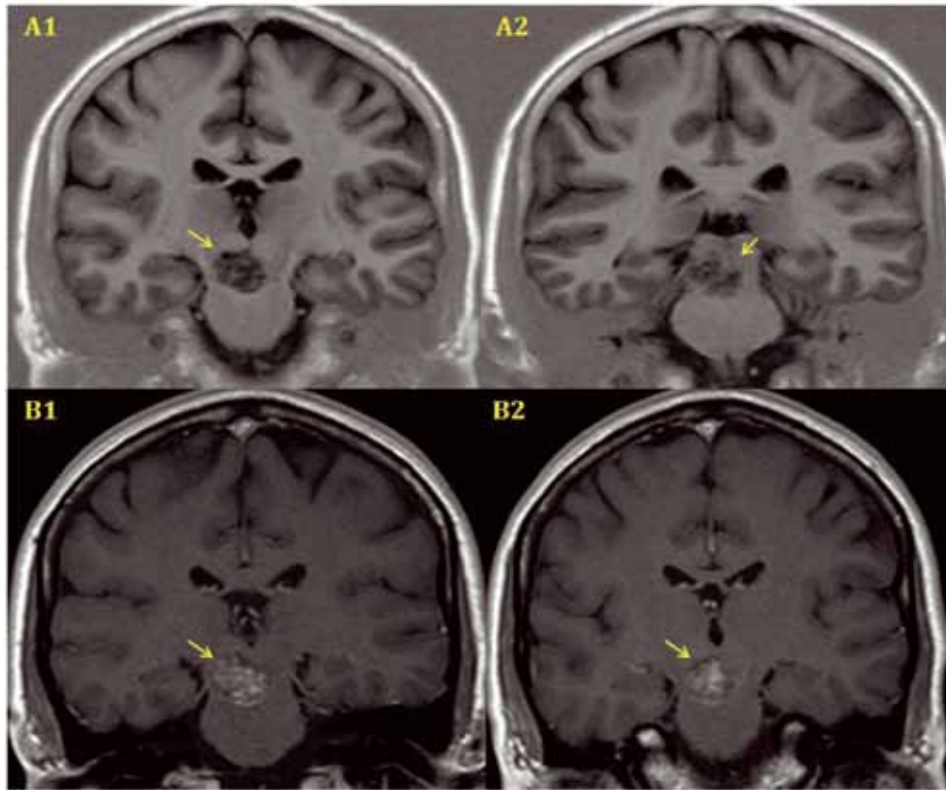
Coronal MRI showing a right mesencephalic cavernoma (arrows) (A1/A2: T1/IR-Weighted; B1/B2: T1-Weighted with Gadolinium contrast).
